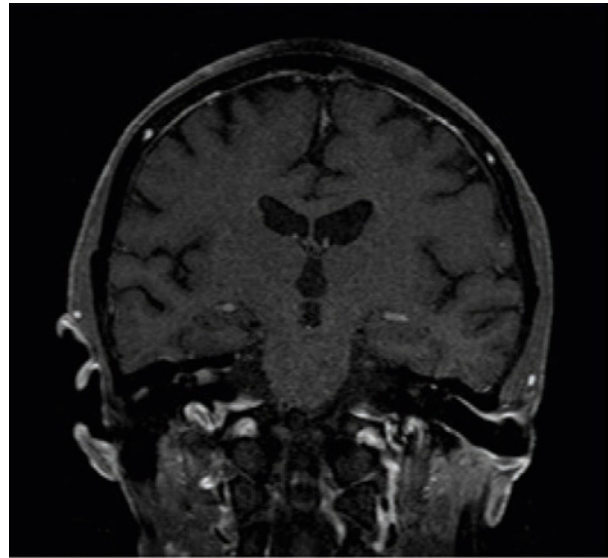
MR imaging with coronal post-gadolinium T1-weighted image with bilateral enhancement of internal acoustic canal.
